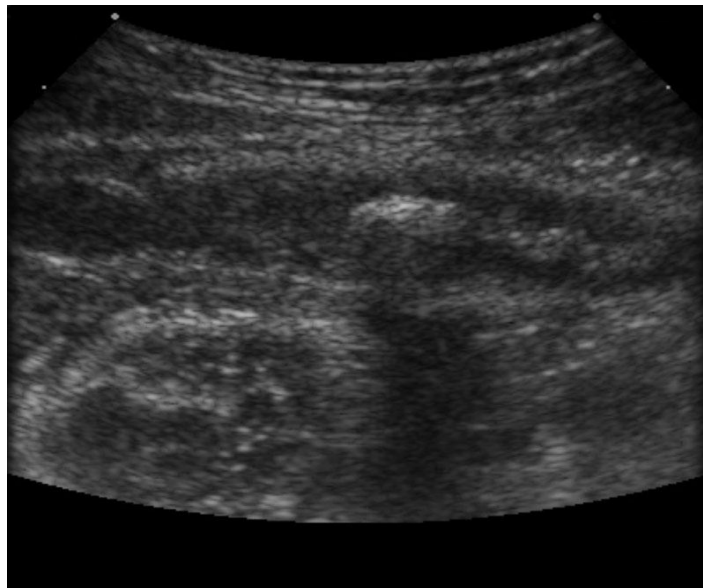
Ultrasound abdomen – Acute Appendicitis with Appendicolith
